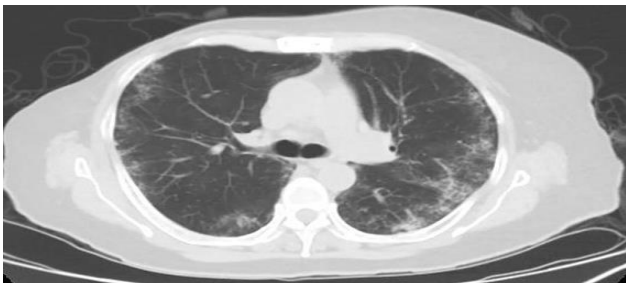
Chest CT: ground-glass opacities in the bilateral upper lobes (axial view).
